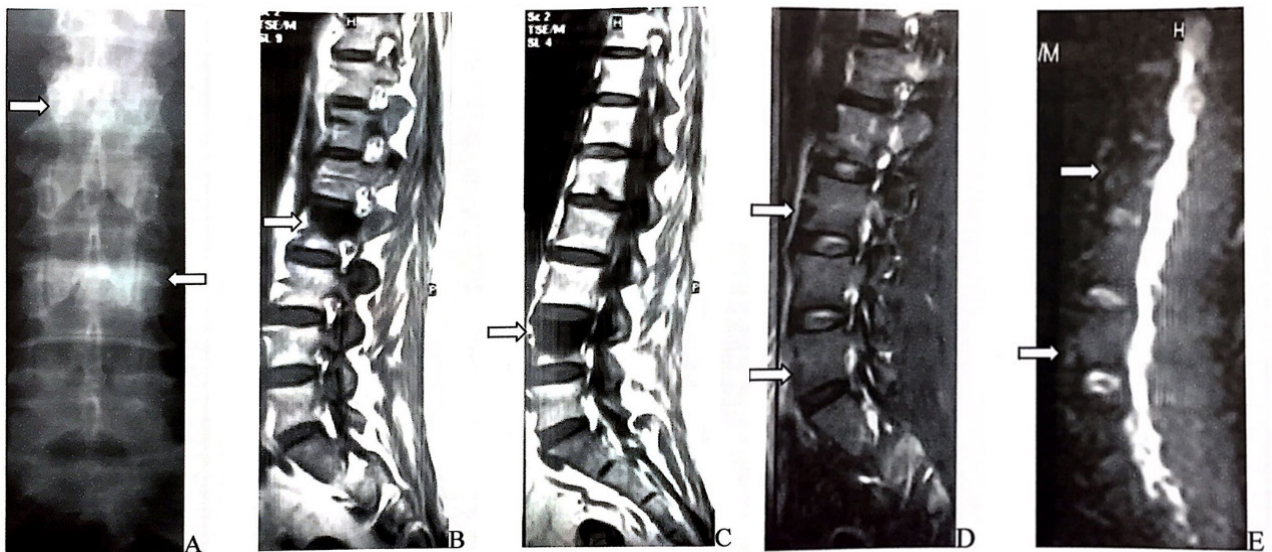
A 53-years-old female patient with breast cancer; (a) on the lumbar X-ray were detected sclerotic lesions on the pedicles of L2 and L4 vertebrae. (b) T1W sagittal image showed a iso-hypointense lesion on the L2 vertebra. (c) T1W sagittal image showed a iso-hypointense lesion on the L4 vertebra. (d) L2 and L4 vertebrae were isointense on T2W sagittal image.
